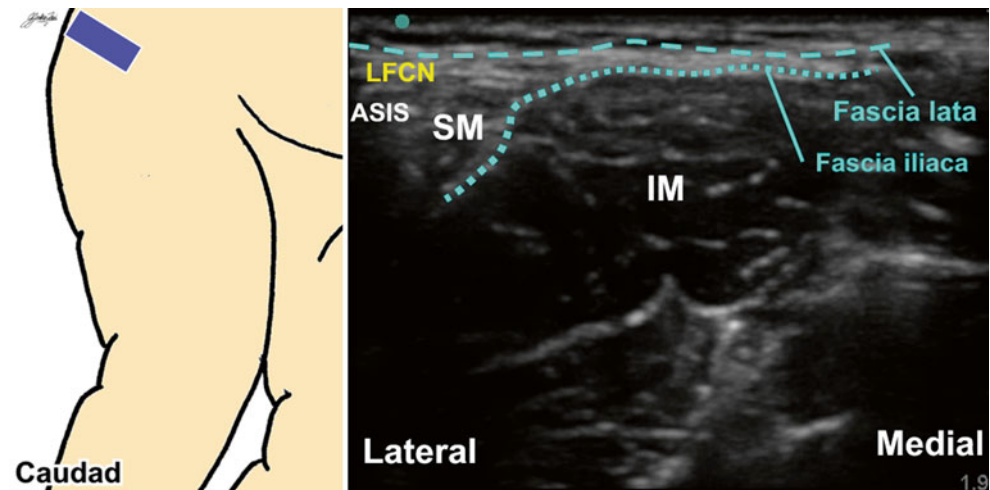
Ultrasound image of the lateral femoral cutaneous nerve (*LFCN*) between the fascia lata and fascia iliaca. *ASIS* anterior superior iliac spine, *SM* sartorius muscle, *IM* iliacus muscle
